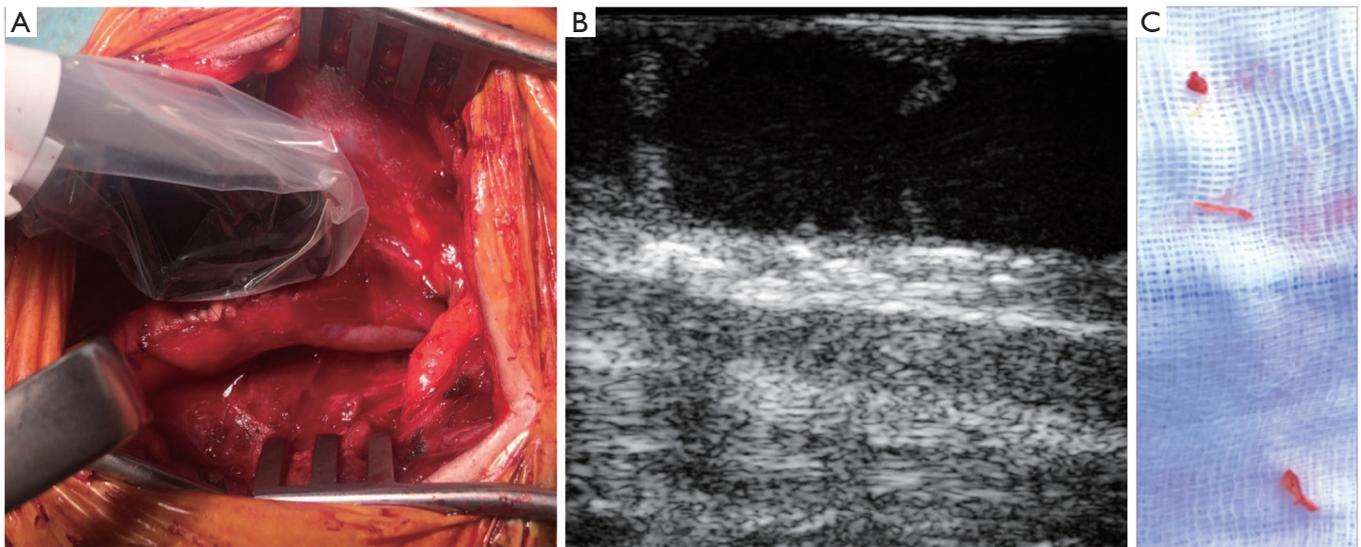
IDUS. Intraoperative setup with the ultrasound probe placed on the carotid artery (A). B-mode ultrasound image (blood flow from right to left) demonstrating various residual intima flaps within the internal carotid artery after carotid endarterectomy (B). Those were confirmed and resected during surgical revision (C). IDUS, intraoperative duplex ultrasound.
